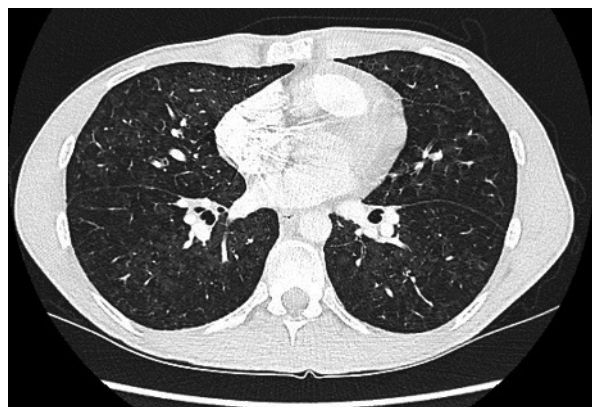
HRCT: Regression of interlobular septa thickening and of pleural fluid after treprostinil therapy
